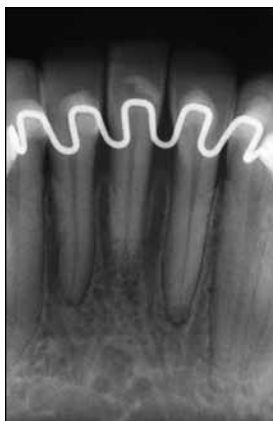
Radiographic aspect showing the presence of interproximal alveolar bone.
